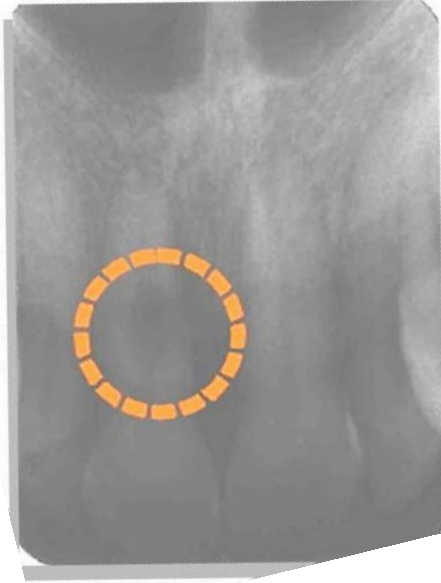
Radiographic examination revealed radio transparent lacuna on the middle third of the root.
